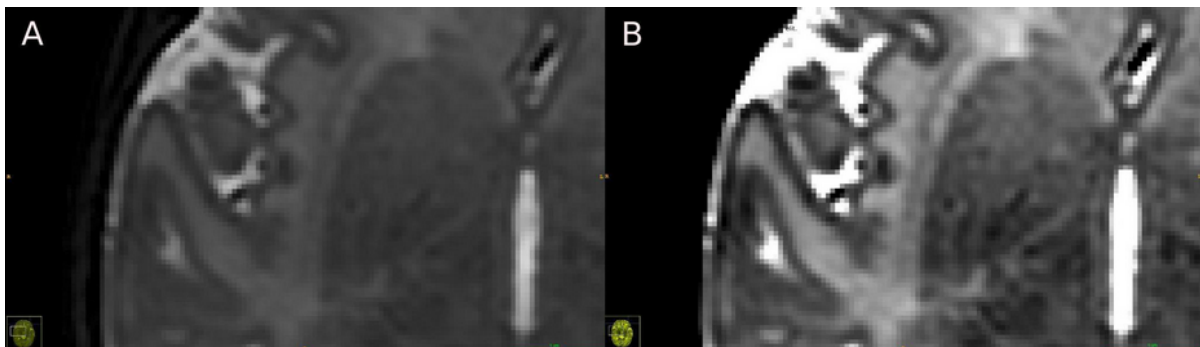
Image section with the right claustrum of a T2-weighted neonatal brain MRI.
